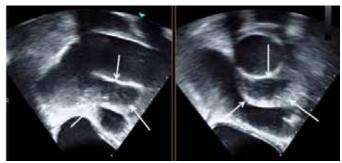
Transesophageal echocardiography (TEE) demonstrating accumulation of fluid (arrows) behind the aortic graft, from the Sino tubular junction to the distal ascending segment of the graft.
